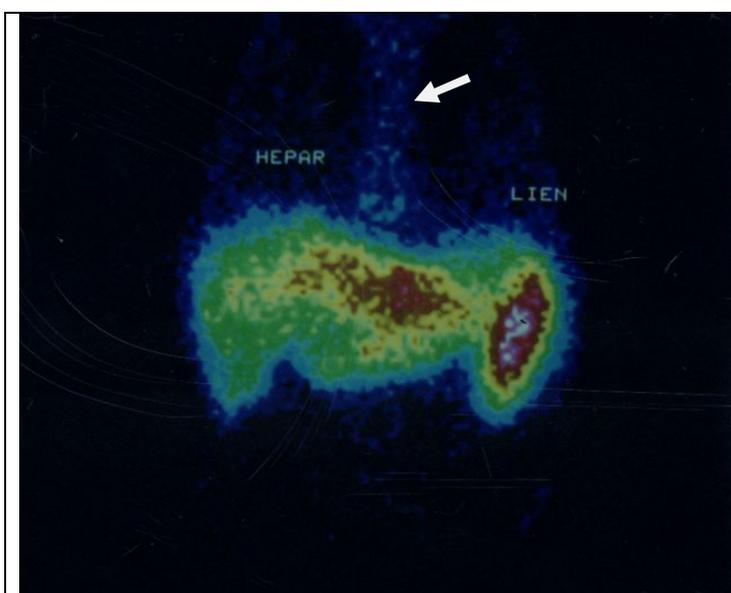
Static scintigraphy
